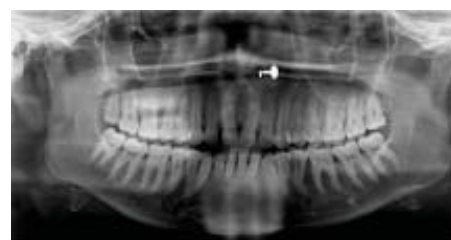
Panoramic radiograph showing multiple irregular calcified structures on left side over ramus of mandible.
